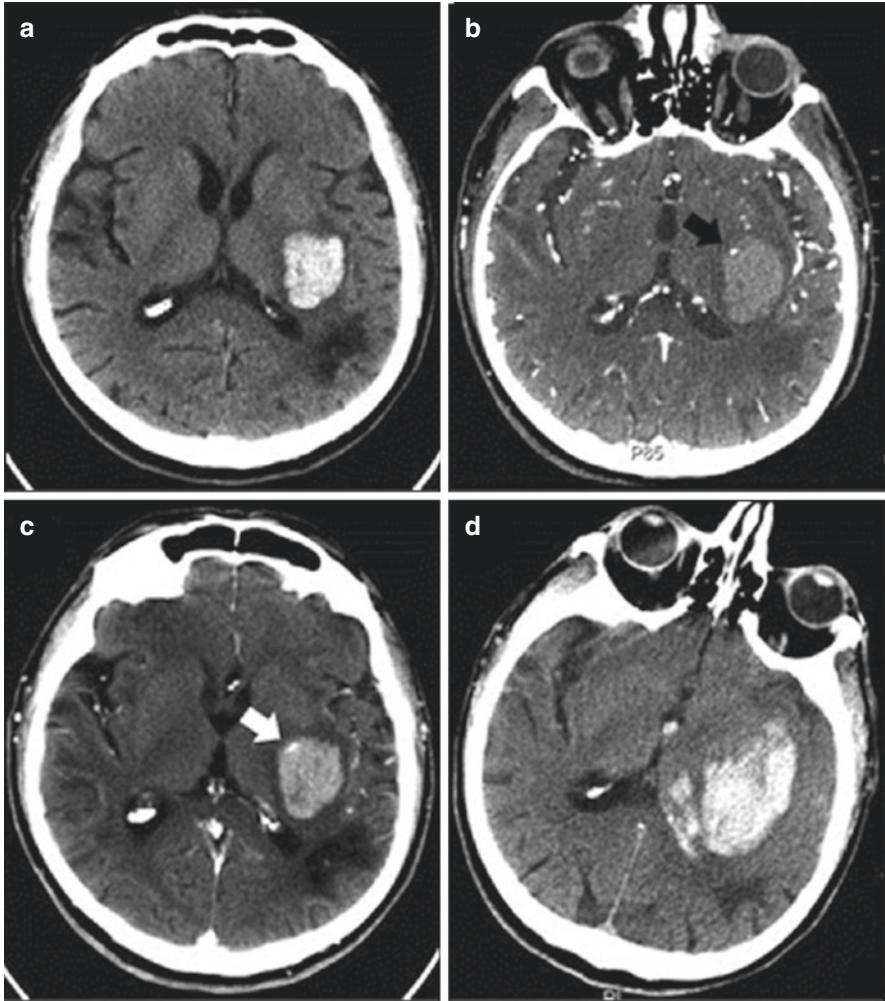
(a) Patient with a spot sign visible in a putaminal ICH. (a) Demonstrates left posterior putaminal ICH with mild surrounding edema. In (b), an arrow indicated the small focus of contrast enhancement seen on CTA consistent with the spot sign. (c) Shows the postcontrast CT wherein the white arrow shows the spot sign has enlarged. (d) Shows an unenhanced CT taken 1 day later showing the development of IVH and expansion of the ICH (Wada et al. [48])
